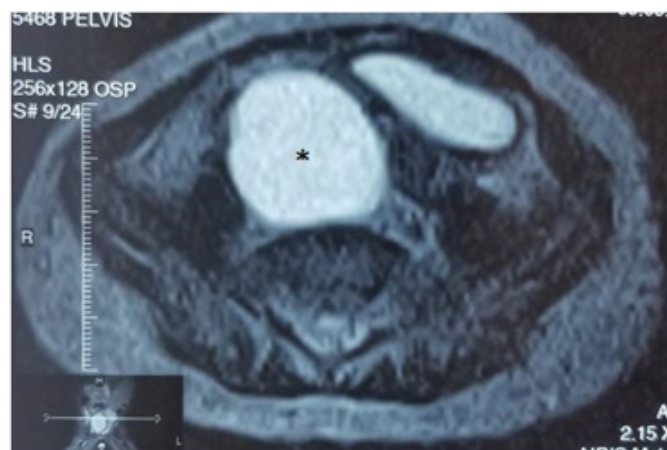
MRI pelvis showing high intensity lesion in the pelvis (asterisk).
